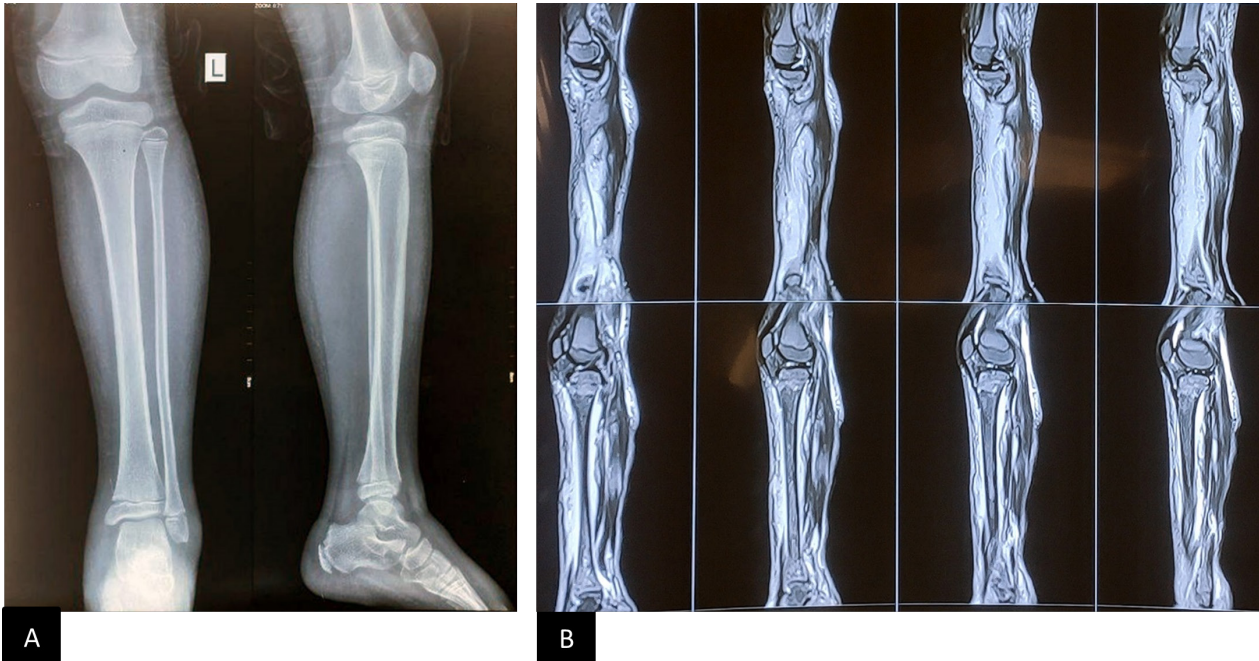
Pre-operative Radiological Imaging (A: X-ray of left leg was normal, B: MRI of the left leg revealed high signal intensity changes in the proximal and distal metaphysis of the left tibia, crossing the growth plate, along with a large sub-periosteal collection mainly on the anteromedial aspect of the tibia, extending to the ankle and foot)
